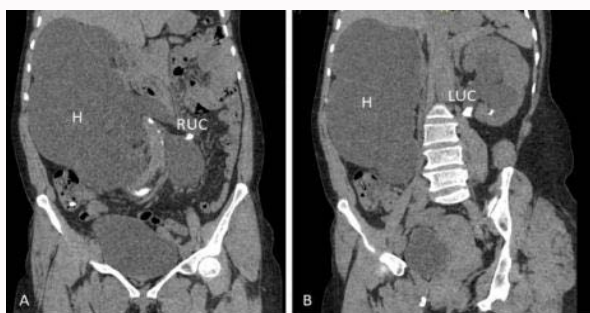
Computed tomography scan showed the (A) right giant hydronephrosis secondary to right upper ureteric calculi, and (B) left moderate hydronephrosis secondary to left upper ureteric calculi. Abbreviation: H: Hydronephrosis; RUC: Right Upper Ureteric Calculi; LUC: Left Upper Ureteric Calculi.
